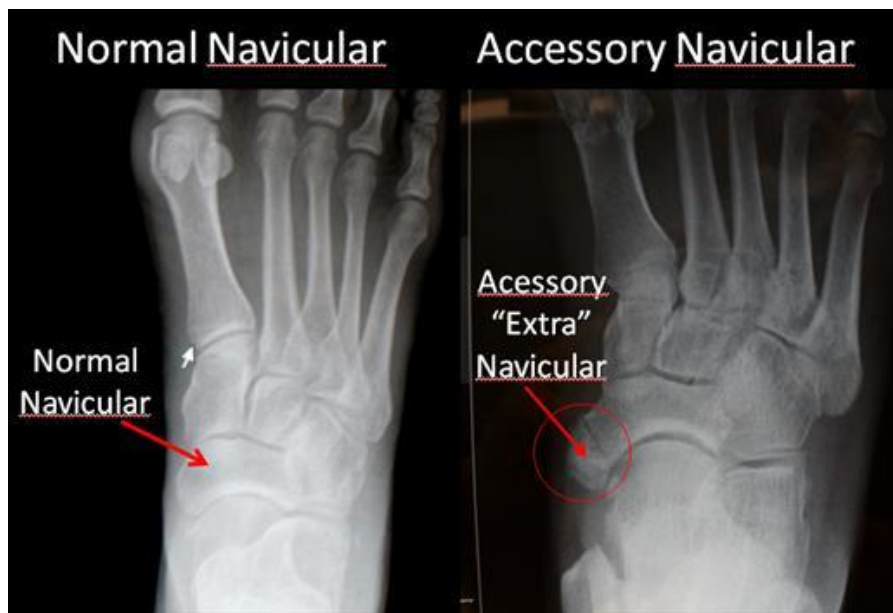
Radiography of accessory navicular. Adapted from e-radiography.net
